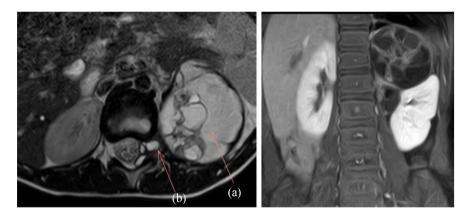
MRI images in axial T2 and coronal T1 sections with fat saturation and after injection of the guadoline contrast product, showing a solidocystic mass of the left adrenal lodge (a) extended intracanal (b).
